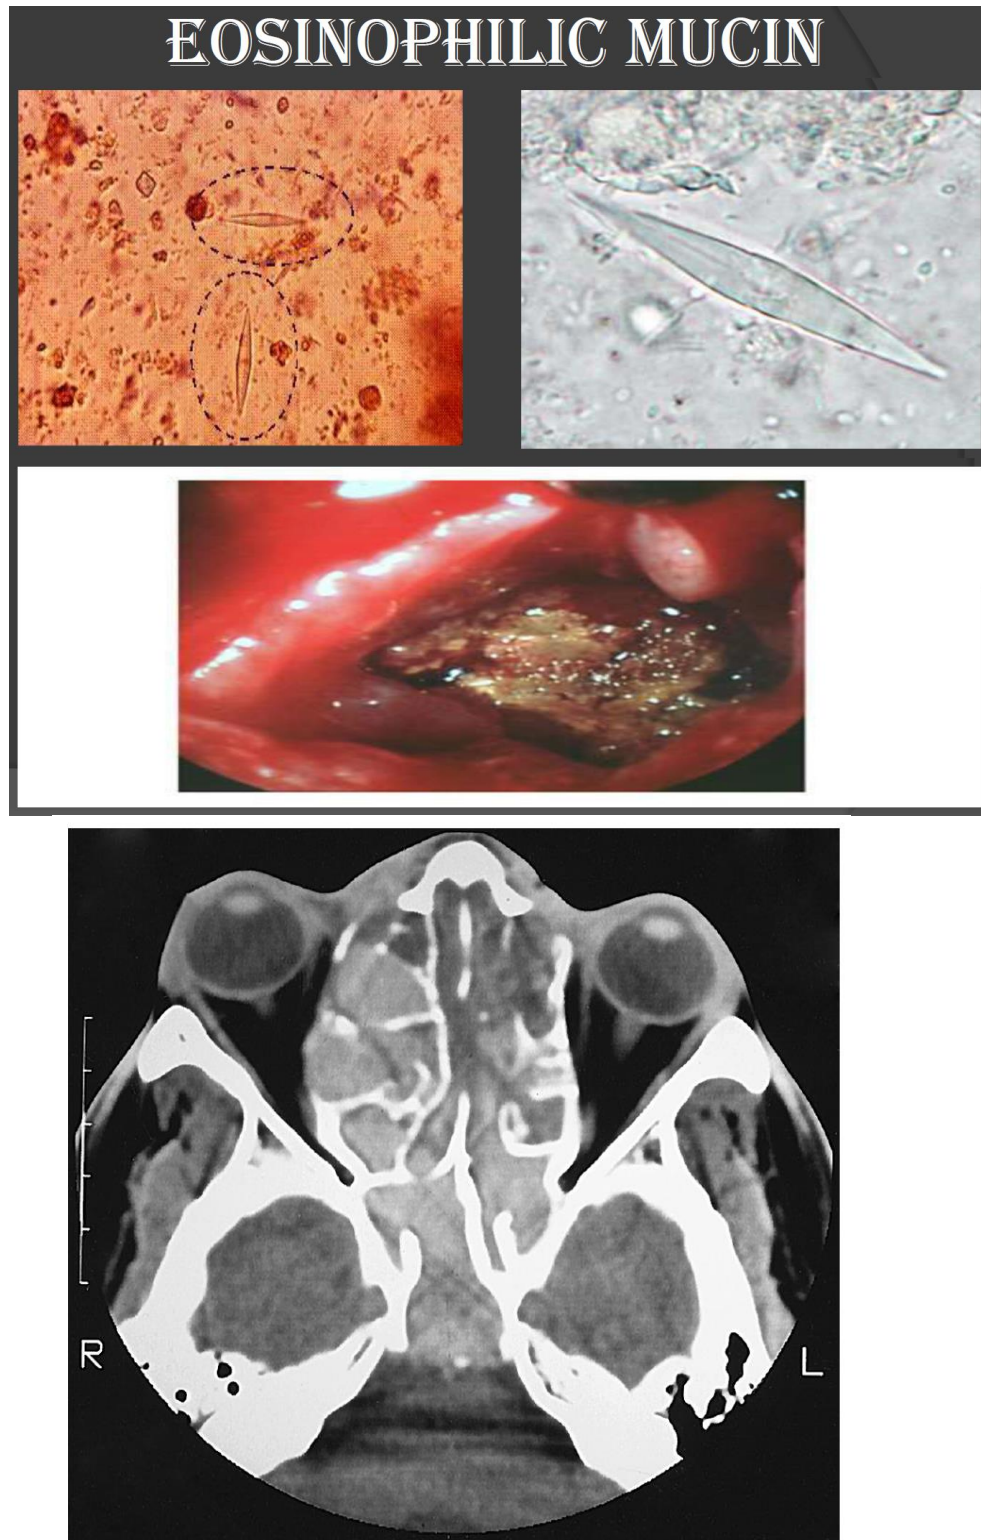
Axial computed tomography scan of a patient with allergic fungal rhinosinusitis. Note the heterogeneity of densities in the ethmoid and bony erosion of right lamina papyracea and the posterior wall of the sphenoid sinus.
